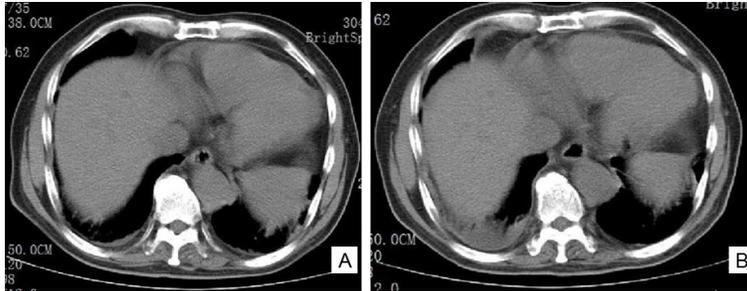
A. Chest CT demonstrates pleural effusion; B. Increased effusions on subsequent chest CT 8 days later.
